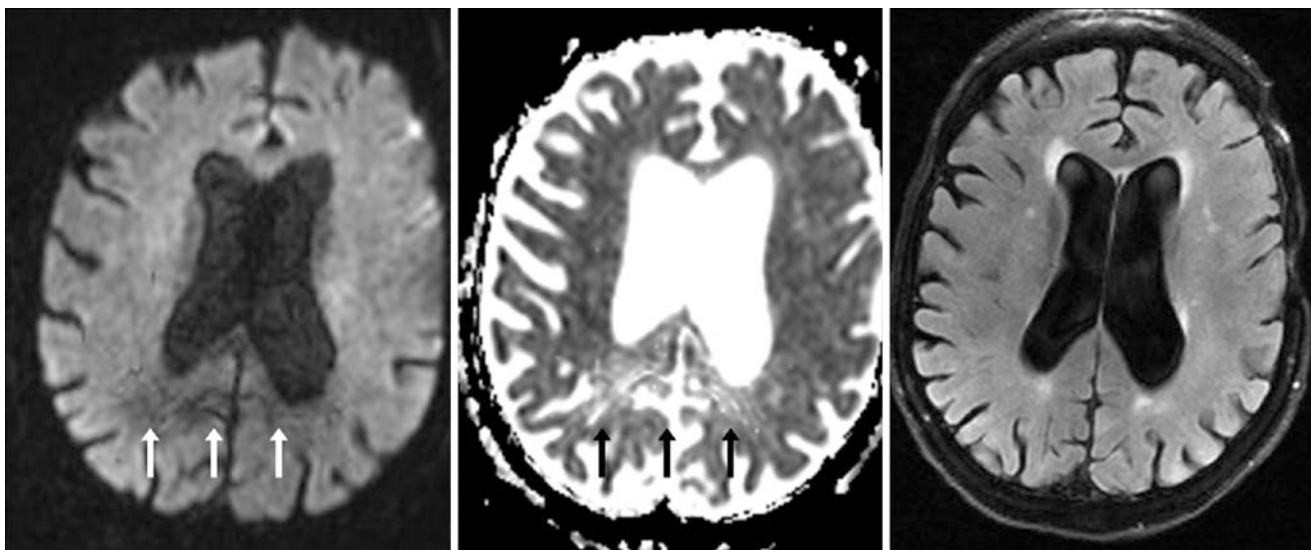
An 85-year-old had a small, focal region of dark artifact within the parieto-occipital region on DWI MRI (*left*) at 3 T, thought related to eddy currents and Lorentz forces (*arrows*); it also could be
